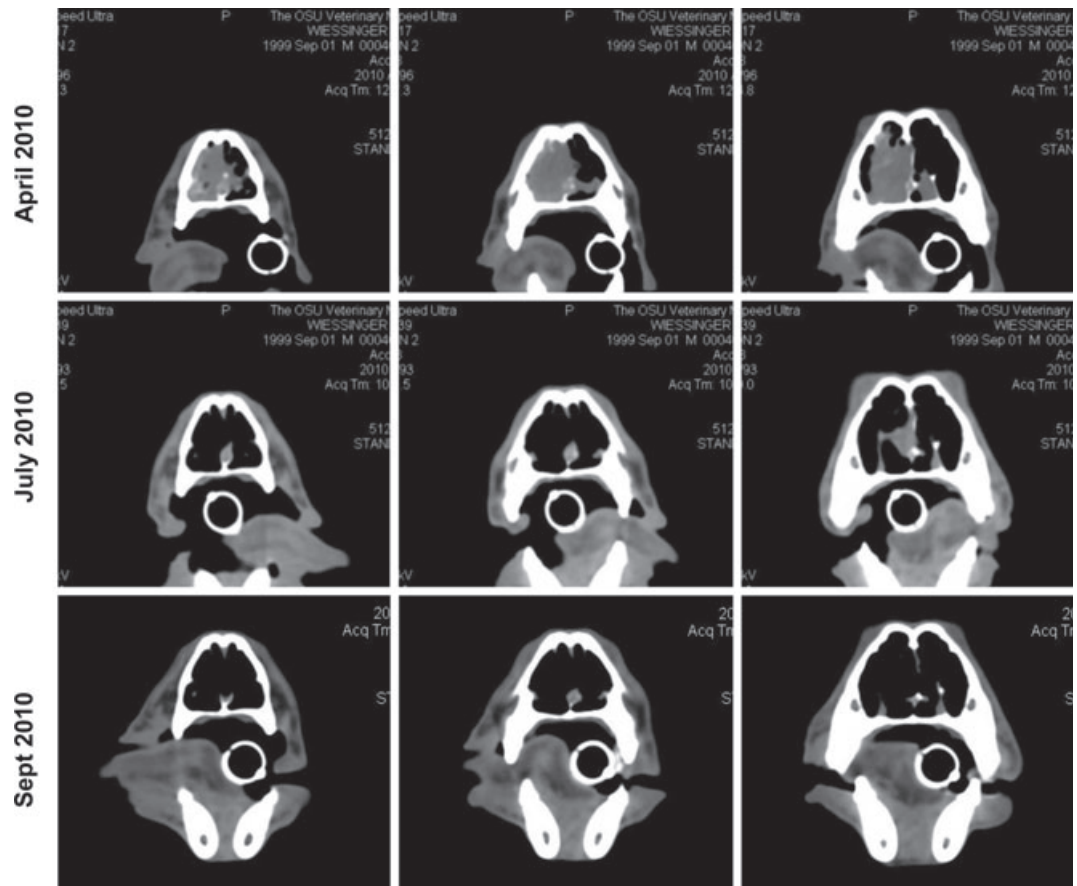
Serial CT demonstrating response of nasal carcinoma to toceranib. An 11-year-old male neutered Shetland sheepdog was treated with toceranib following recurrence of a nasal carcinoma after initially responding to radiation therapy in January 2010. Shown are serial matched images of the nasal cavity 3 (July 2010) and 5 (September 2010) months after beginning toceranib therapy in April 2010.
